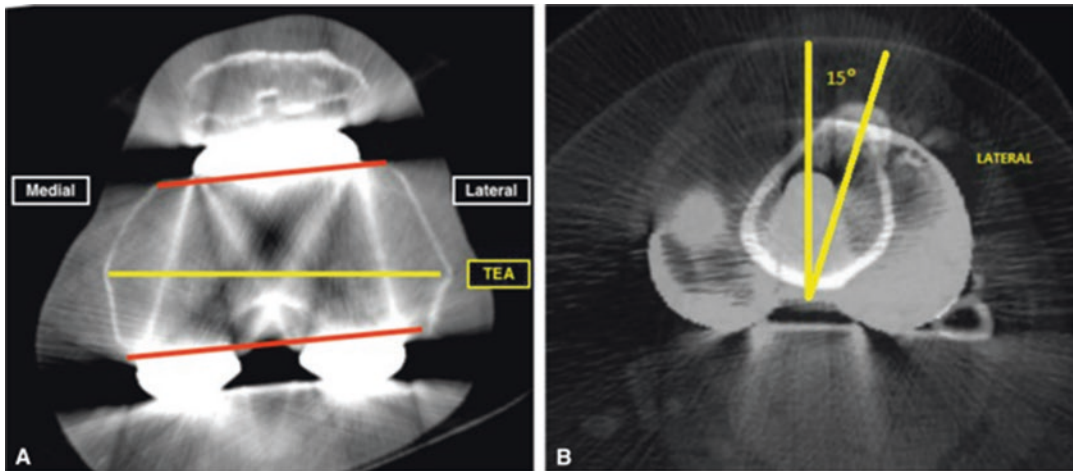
Implant malposition can lead to patellar mal-tracking, limited range of motion, and pain. To evaluate implant position, a CT scan of the knee is most helpful.
